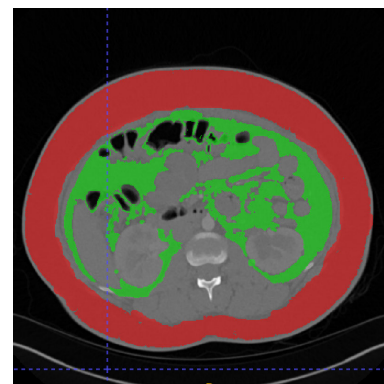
Example Segmentation overlay on DICOM image of a single CT slice through the abdomen (ITK-SNAP). Green: Visceral adipose tissue, Red: Superficial adipose tissue. Other: Background.
